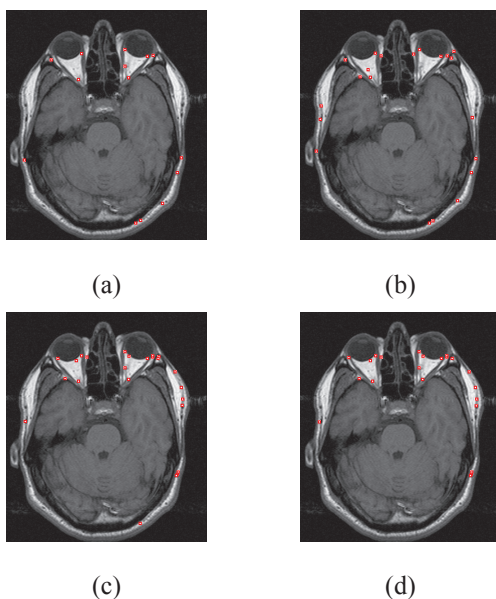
Results of landmark detection for a MR image of a human brain (slice 12) using the following interest point detectors: (a)  $f_1$ ; (b)  $f_2$ ; (c)  $f_3$ ; (d)  $f_4$ .
